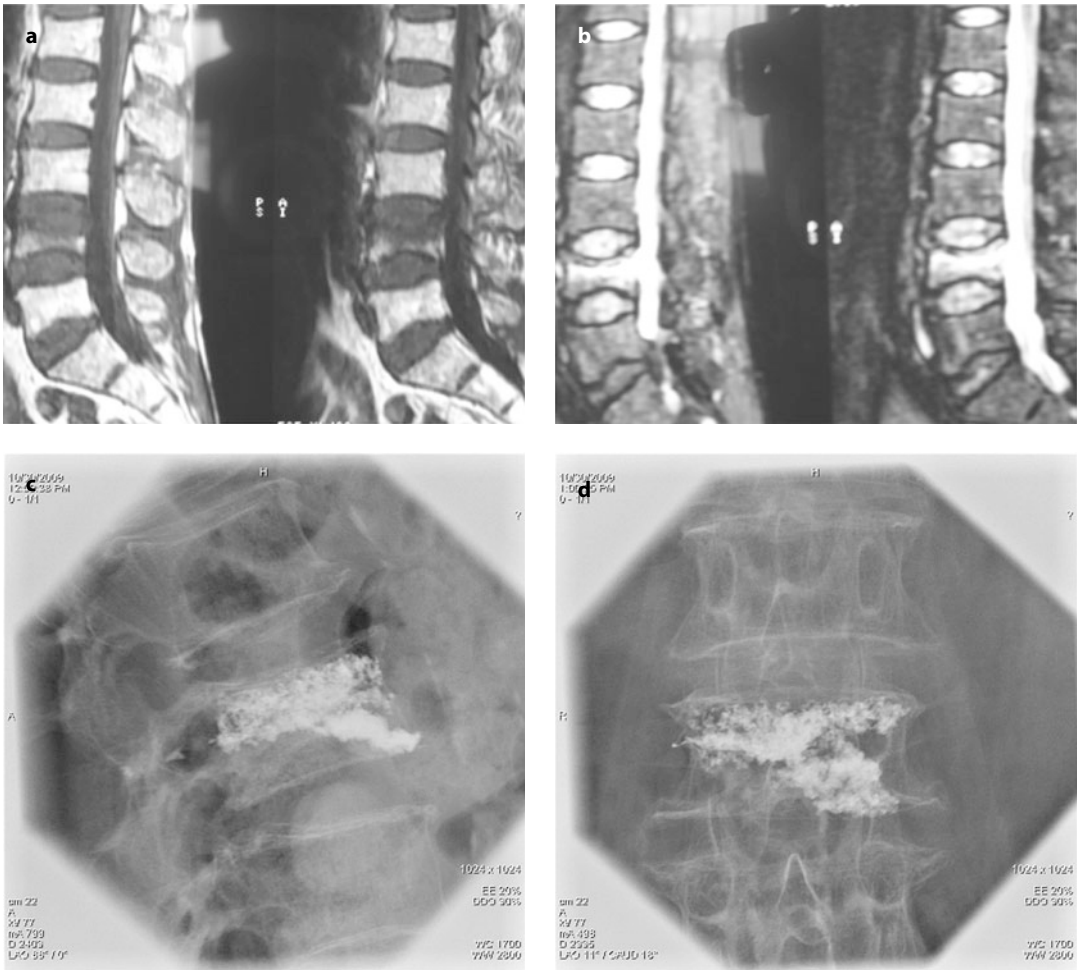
55-year-old male with a vertebral fracture at the L4 level. Sagittal T1-weighted MRI shows a vertebral fracture at the L4 level with hypointense signals (a). Sagittal T2-STIR MRI shows the hyperintense signal due to bone-marrow edema (b). Left lateral and anteroposterior views under fluoroscopic control after VP of the L4 treated by cement (Kryptonite™) do not show venous or disk leakage (c and d)
